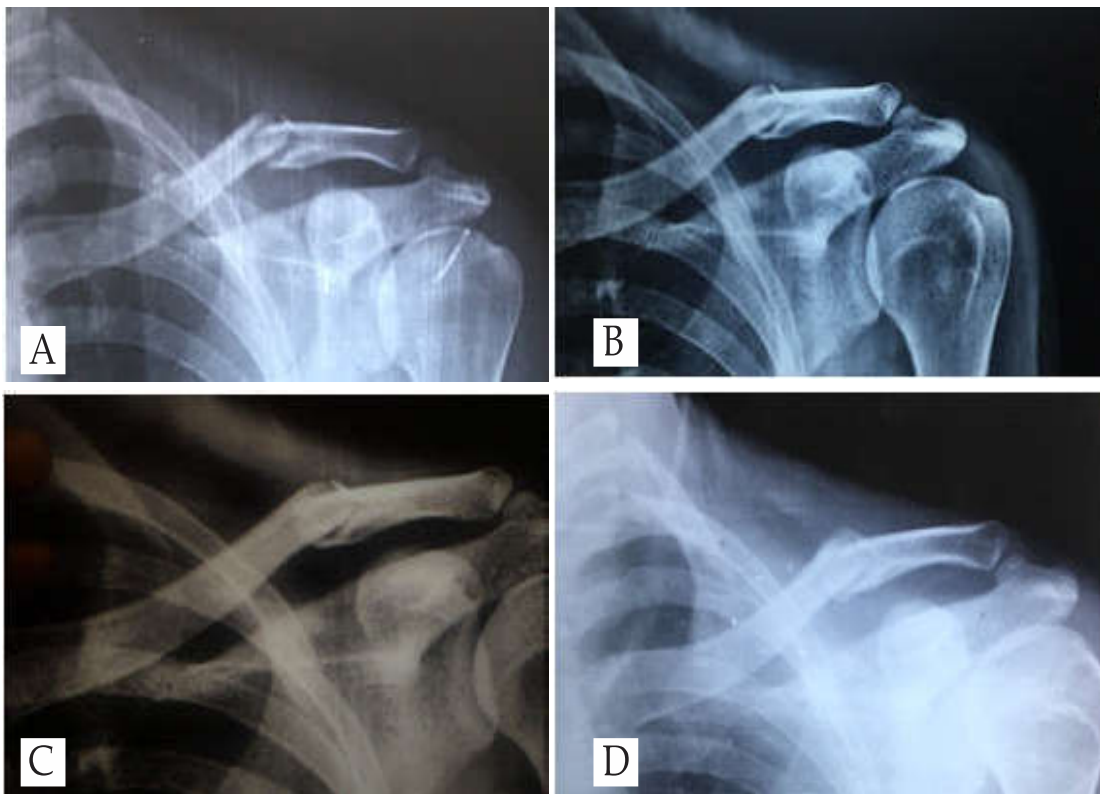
Case-1 Radiograph a. post trauma, b. 6 weeks f/u, c.10 weeks f/u, d.union
